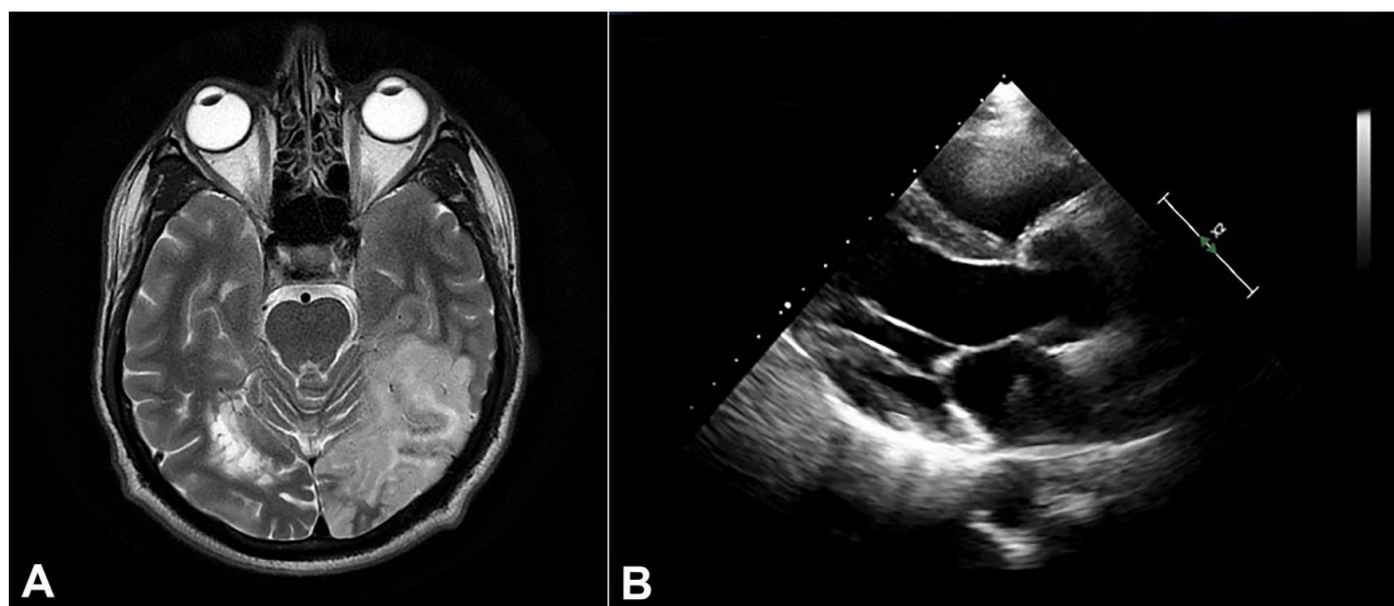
A – NCCT brain showing an acute wedge-shaped infarct in left hemisphere, B – Transesophageal echocardiography (TEE) showing a left atrial mass arising from Interatrial septum.
